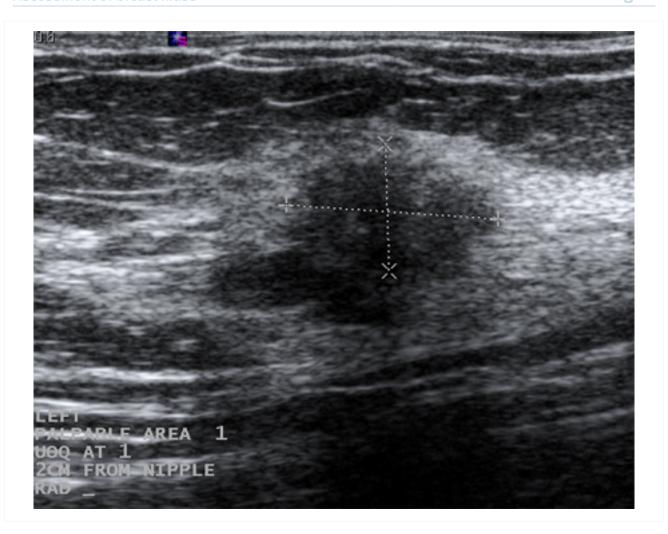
Ultrasonographic image of an invasive carcinoma
